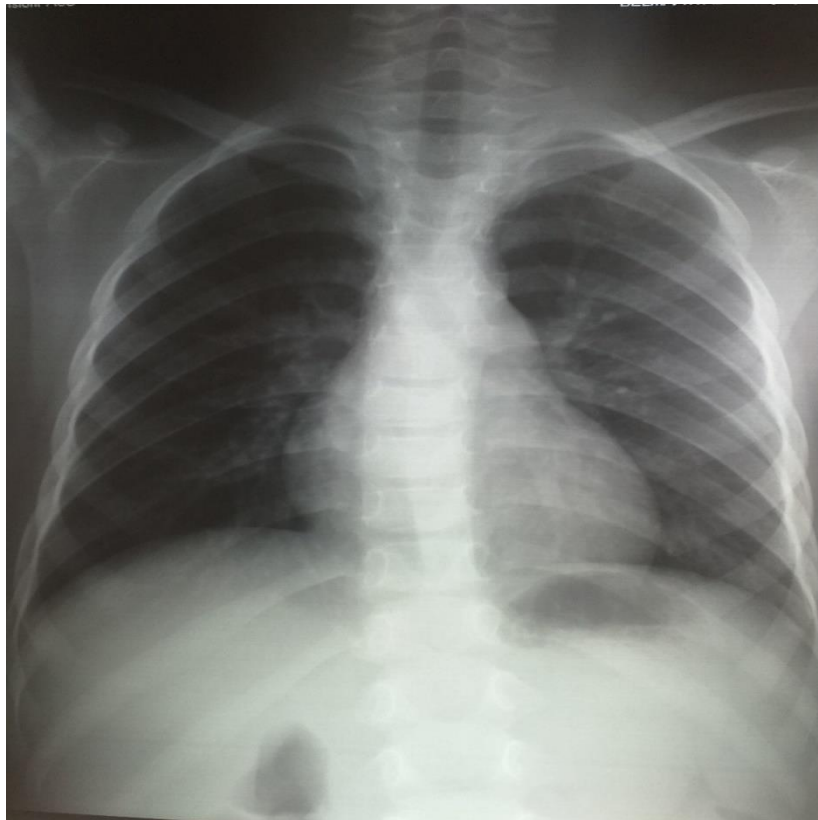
Chest x-ray, no active focus
